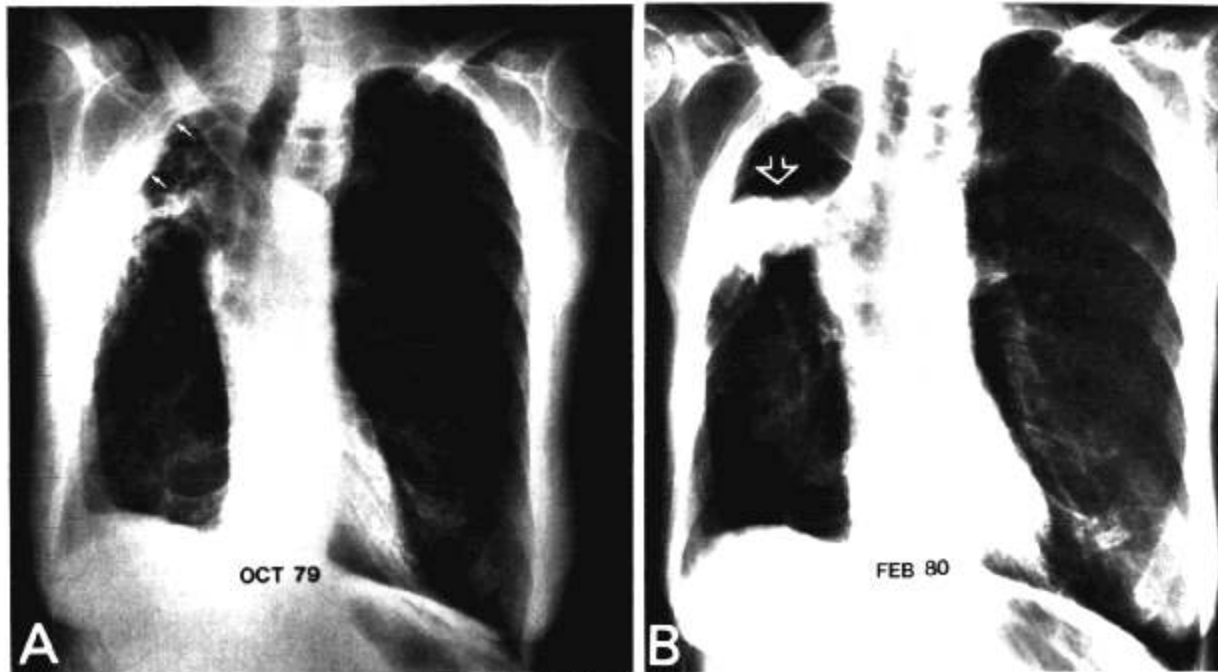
A. PA Chest Roentgenogram (October 1979) (Case 3). Right lateral and apical pleural thickening (arrows) as well as a poorly defined right upper lung zone infiltrate are present in this patient. A right sided thoracotomy had been performed 4 years prior to this radiograph. B. PA Chest Roentgenogram (February 1980). The right upper lung zone is now occupied by a large cystic space. Its superior and lateral aspect are marginated by thickened pleura. In the inferior aspect of this cavity a mass lesion has appeared which is capped by air (open white arrow). Decubitus views demonstrated the mobility of this intracavitary mycetoma.
